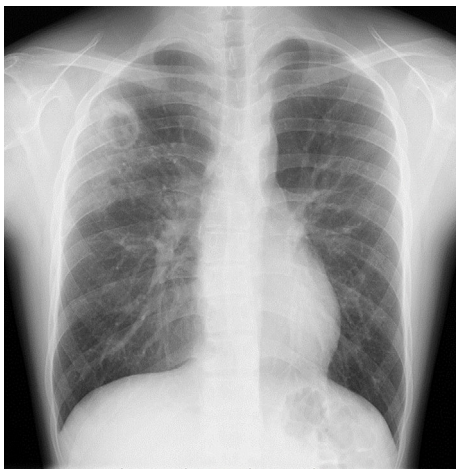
Chest X-ray (day 5) showed a cavity with consolidation in the right upper lung field.
